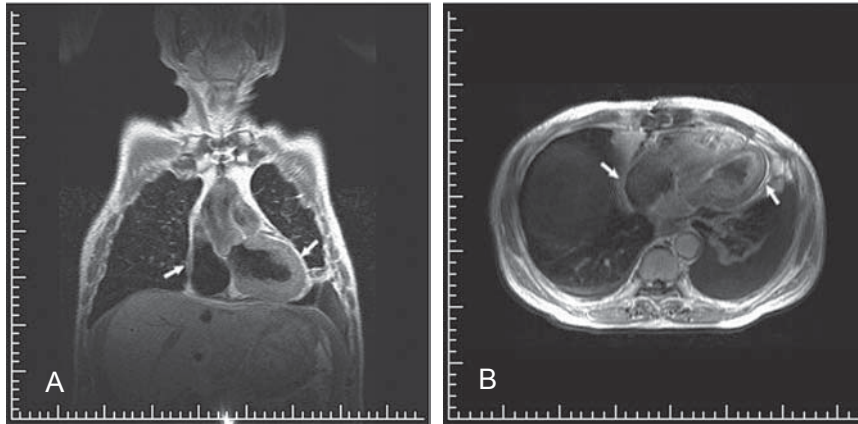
Axial (A) and coronal (B) T1-weighted magnetic resonance images showing an area of high signal intensity, which represents the thickening of the pericardium (maximal thickness of the pericardium was about 5 mm; indicated by arrow).
